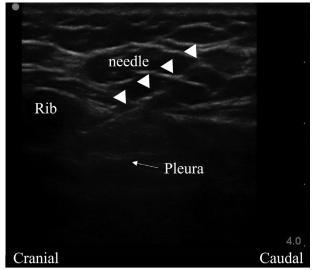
Ultrasound image of the DPIP block. DPIP, deep parasternal intercostal plane.
